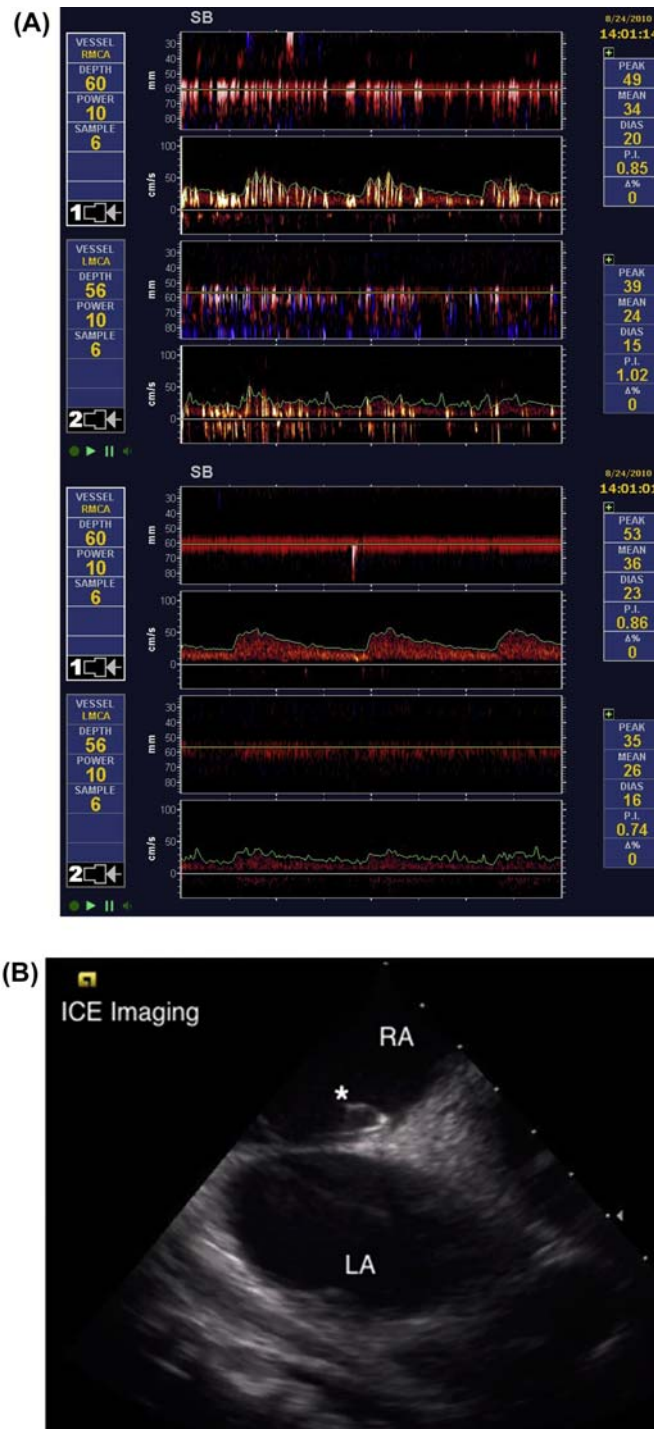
(A) Transcranial Doppler of the bilateral middle cerebral arteries shows a grade 1 right-to-left shunt at rest (bottom) which increases to grade 4 with Valsalva (top), indicating a PFO or transpulmonary shunt. (B) An intracardiac echocardiography (ICE) image of a 0.038'' J-tipped guidewire (marked with an asterisk), which is echo bright at the top of the image, slides along the septum, but will not cross between the septum primum and secundum. (C) Balloon sizing of the PFO confirms a small PFO. The white arrow shows the small waist on the balloon. RA, right atrium, LA, left atrium.
